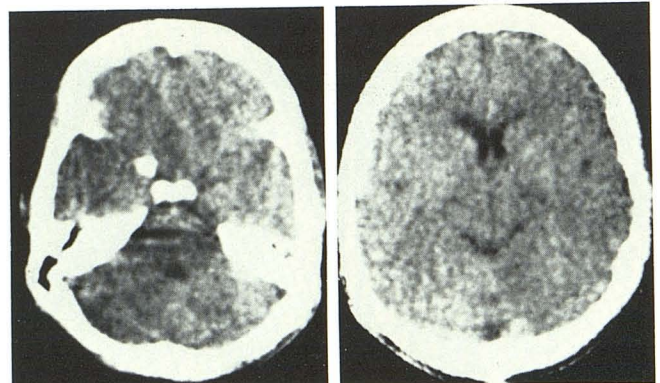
Case 5. CT before (A) and after (B) contrast. Low density in brainstem, patchy hemorrhagic density in left brachium pontis (arrow), and obliteration of posterior fossa cisterns.
